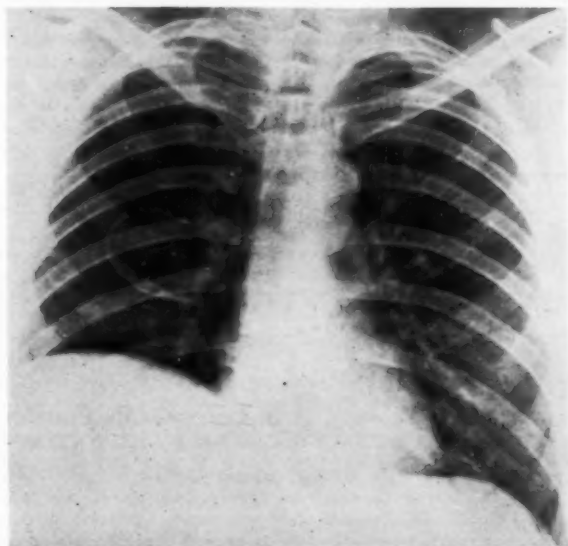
Chest roentgenogram taken one year prior to admission showing solitary pulmonary cyst in right lower lobe.
